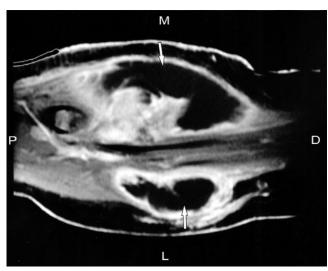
MRI showing sagittal view of right forearm with arrows pointing towards the cystic collections tracking into the forearm. M: medial, L: lateral, P: proximal, D: distal end of the right forearm.
